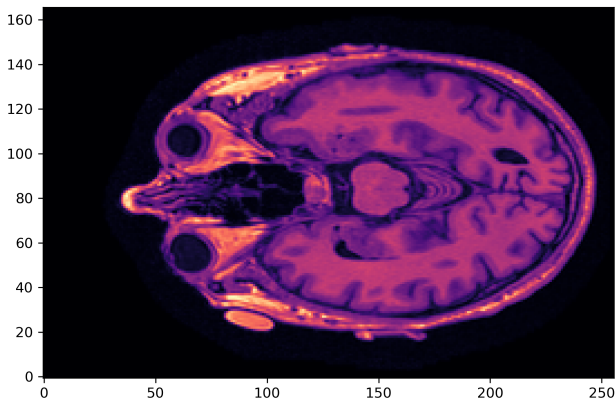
Transversal Layer of an MRI Brain Scan before SynthStrip
